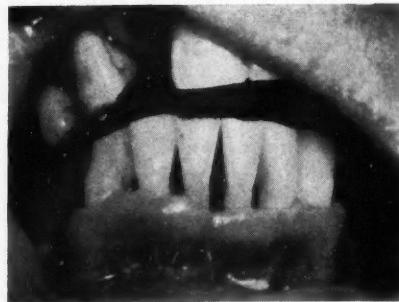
Same case as in Fig. 9, one week after ultrasonic curettage. There is marked shrinkage of the gingivæ.
